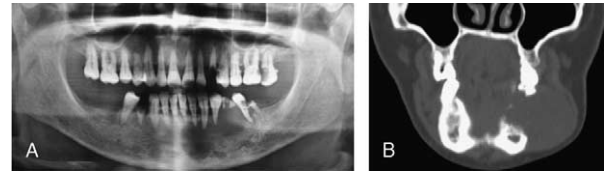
A, Panoramic image showing the area affected by the lesion with osteolysis, root resorption of the 33, destructive tooth decay with resorption of the furcation of 36. B, Mandibular tumor involvement in coronal computed tomography projection.
